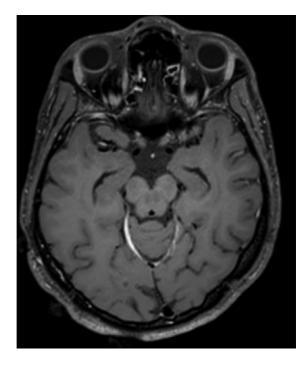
Axial Brain MRI with no vessel wall enhancement.
